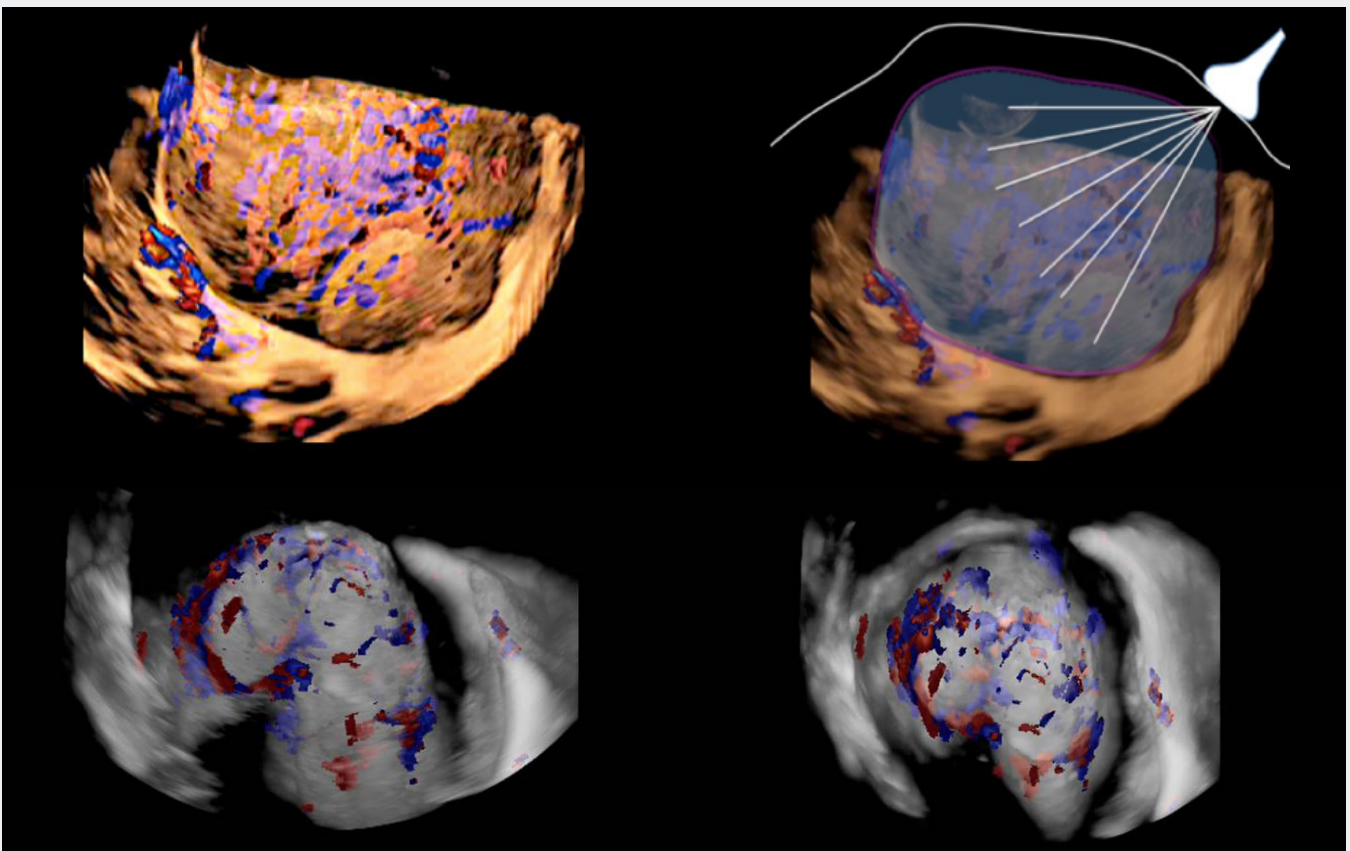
Virtual Cystoscopy : 3D sonographic virtual cystoscopy shows a widespread vascularization of the uterine serosa-bladder interface with an unthinned bladder mucosa (early percreta). The pictures show a remarkable vascularization of the surface of the bladderline
